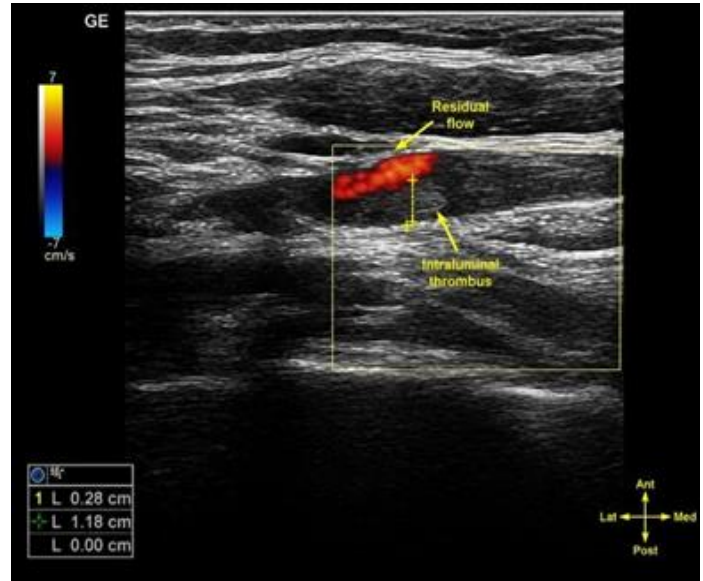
Color Doppler ultrasonography demonstrating partial recanalization of the left internal jugular vein. Color Doppler ultrasonography demonstrating residual blood flow surrounding the intraluminal thrombus (arrow), consistent with a partially occlusive left internal jugular vein thrombosis.
